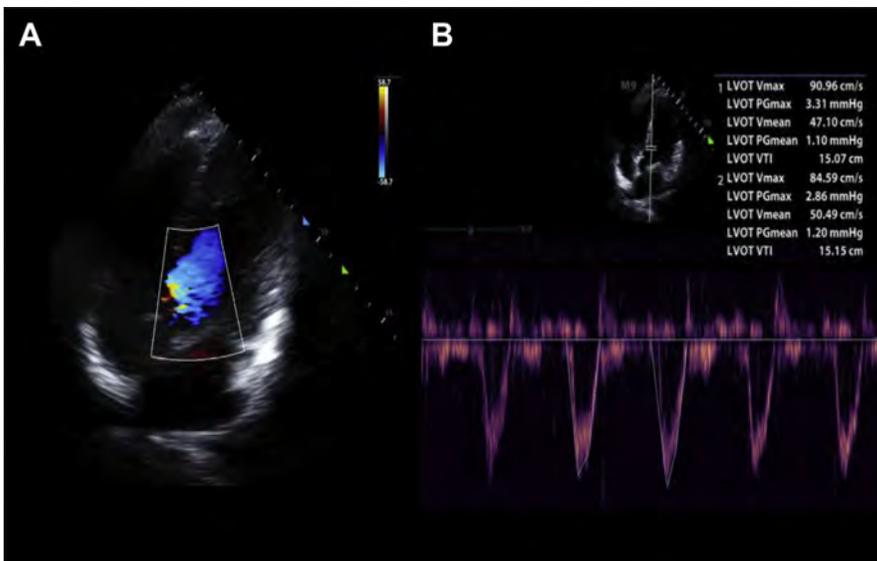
Measurement of the VTI using PW Doppler for SV estimation. (A) After developing a 5-chamber view, CF Doppler is used to visualize the center of laminar flow into the LVOT. Blue denotes flow away from the probe. (B) The sample volume of PW Doppler is positioned at the LVOT aiming for an angle of insonation of less than 15 degrees to avoid underestimation of velocity. At least two or three envelopes are traced to improve accuracy, and the average calculated VTI is used to estimate the SV. Once the LVOT diameter and VTI are known with these methods, the SV can be estimated using the formula: $SV = \pi [LVOT\ diameter/2]^2 \times [LVOT-VTI]$. CF, color flow.
